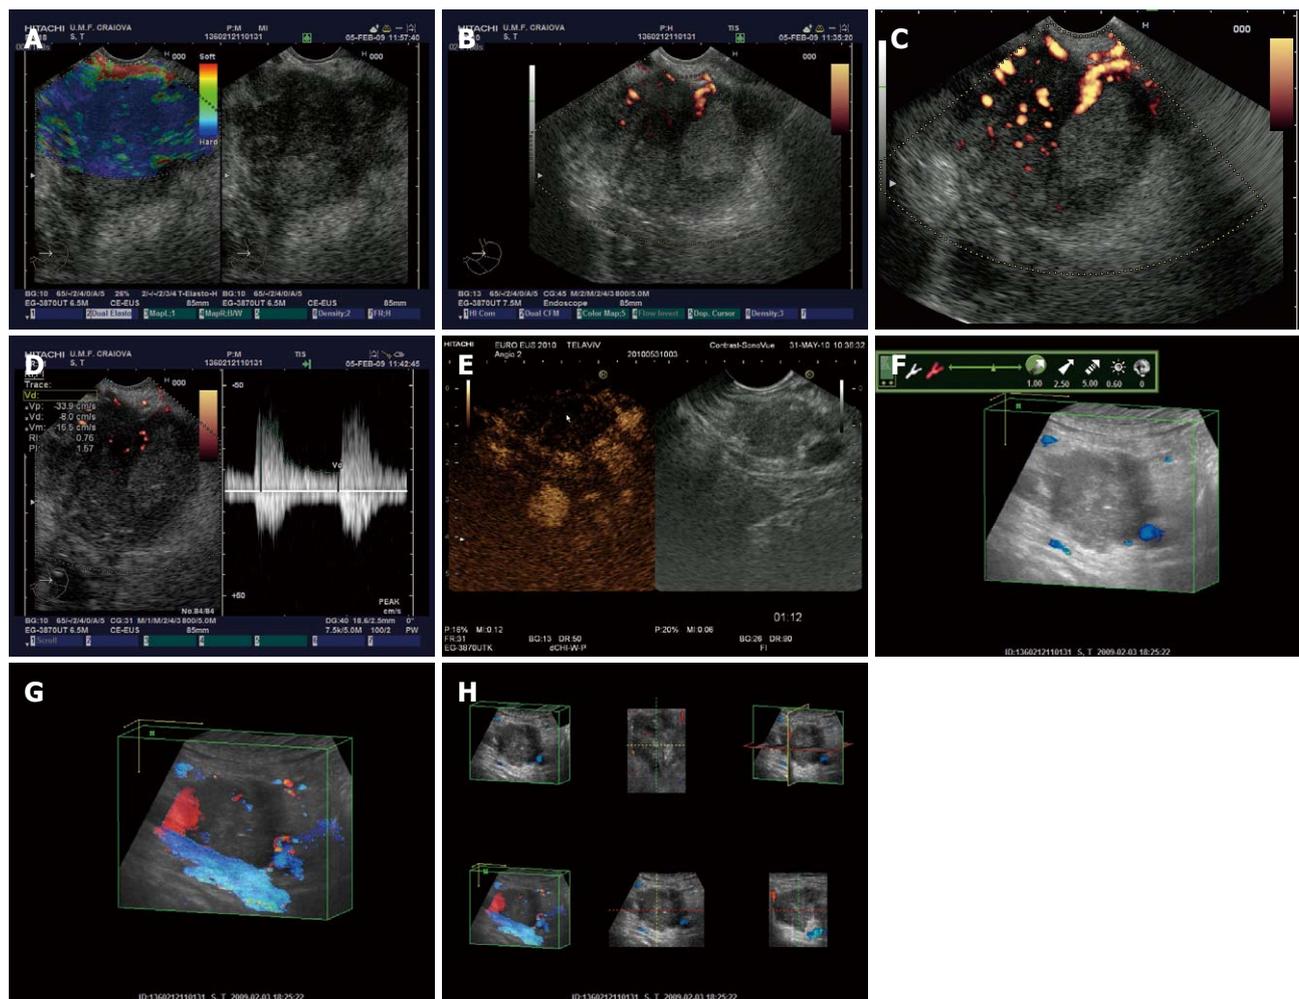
Pancreatic carcinoma at the level of pancreatic head depicted by different endoscopic ultrasound imaging techniques. A: Real-time elastography showing an in-homogenous hard mass; B: Power Doppler endoscopic ultrasound (EUS) without contrast-enhancement; C: Power Doppler EUS after contrast-enhancement with Sono-Vue, showing a hypovascular mass; D: Pulsed Doppler (triplex mode) after contrast-enhancement, with high resistivity and pulsatility indexes of intratumoral arteries; E: Contrast-enhanced low-mechanical index EUS harmonic imaging, showing a hypovascular appearance in the late (venous) phase; F: Tridimensional EUS showing an enhanced image in the opacity mode; G: Transparency mode obtained after contrast-enhancement with Sono-Vue; H: Multiview tridimensional (3D)-EUS display of the pancreatic tumor.
